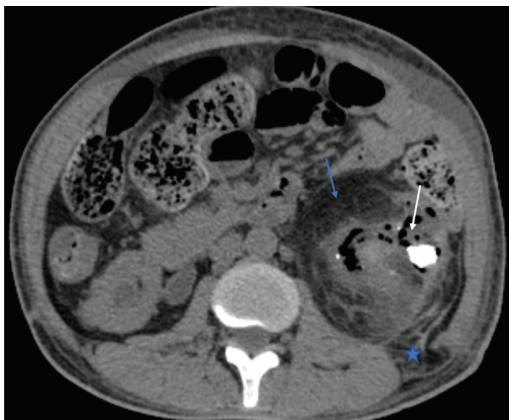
Axial non contrast CT image shows multiple collections with air foci and large calculus within left renal pelvicalyceal system (white arrow). Fatty replacement of renal pelvis (blue arrow) and extension into posterolateral abdominal wall (blue star).
